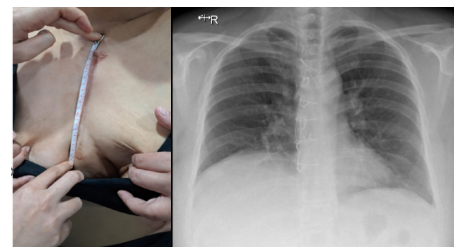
Healed midline sternotomy scar and chest x-ray showing no focal cardiopulmonary abnormality and postoperative sternal wires
